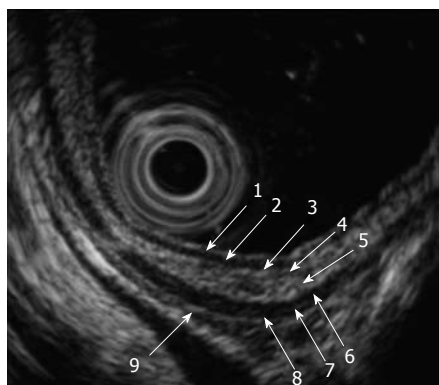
Endoscopic ultrasound features of normal esophageal wall. Each numbered circle, 1-9, with a white arrow, indicates the corresponding numbered tissue layer, first through ninth.
